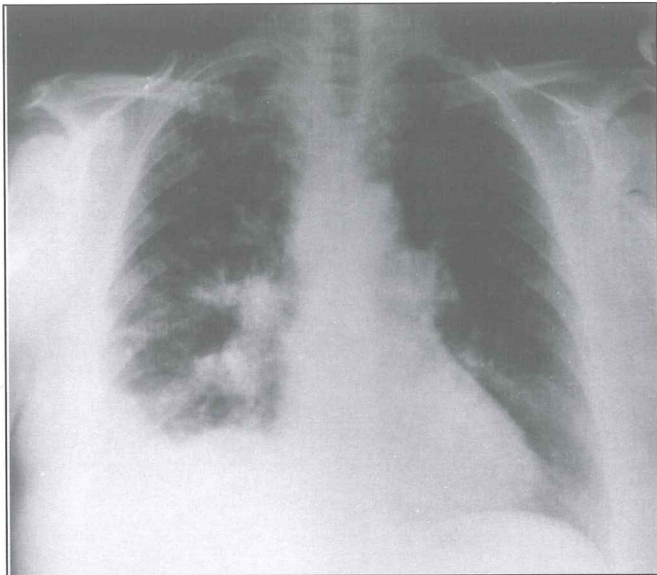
Chest X-ray of the patient at the end of the first month of antituberculosis therapy.
